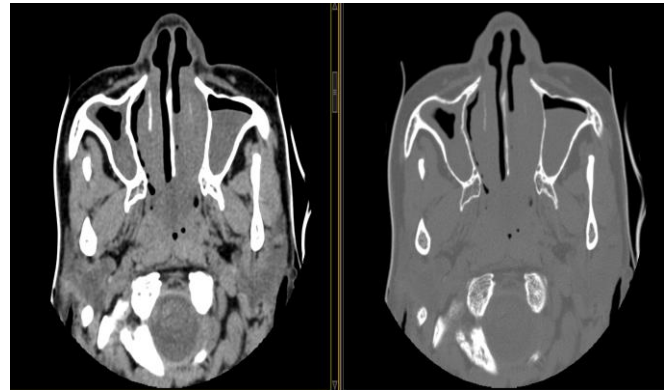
Axial CT of the antra showing mucosal thickening of the right antrum, an isodense lesion in the inferior two-third of the left antrum and enlarged nasal turbinates.
